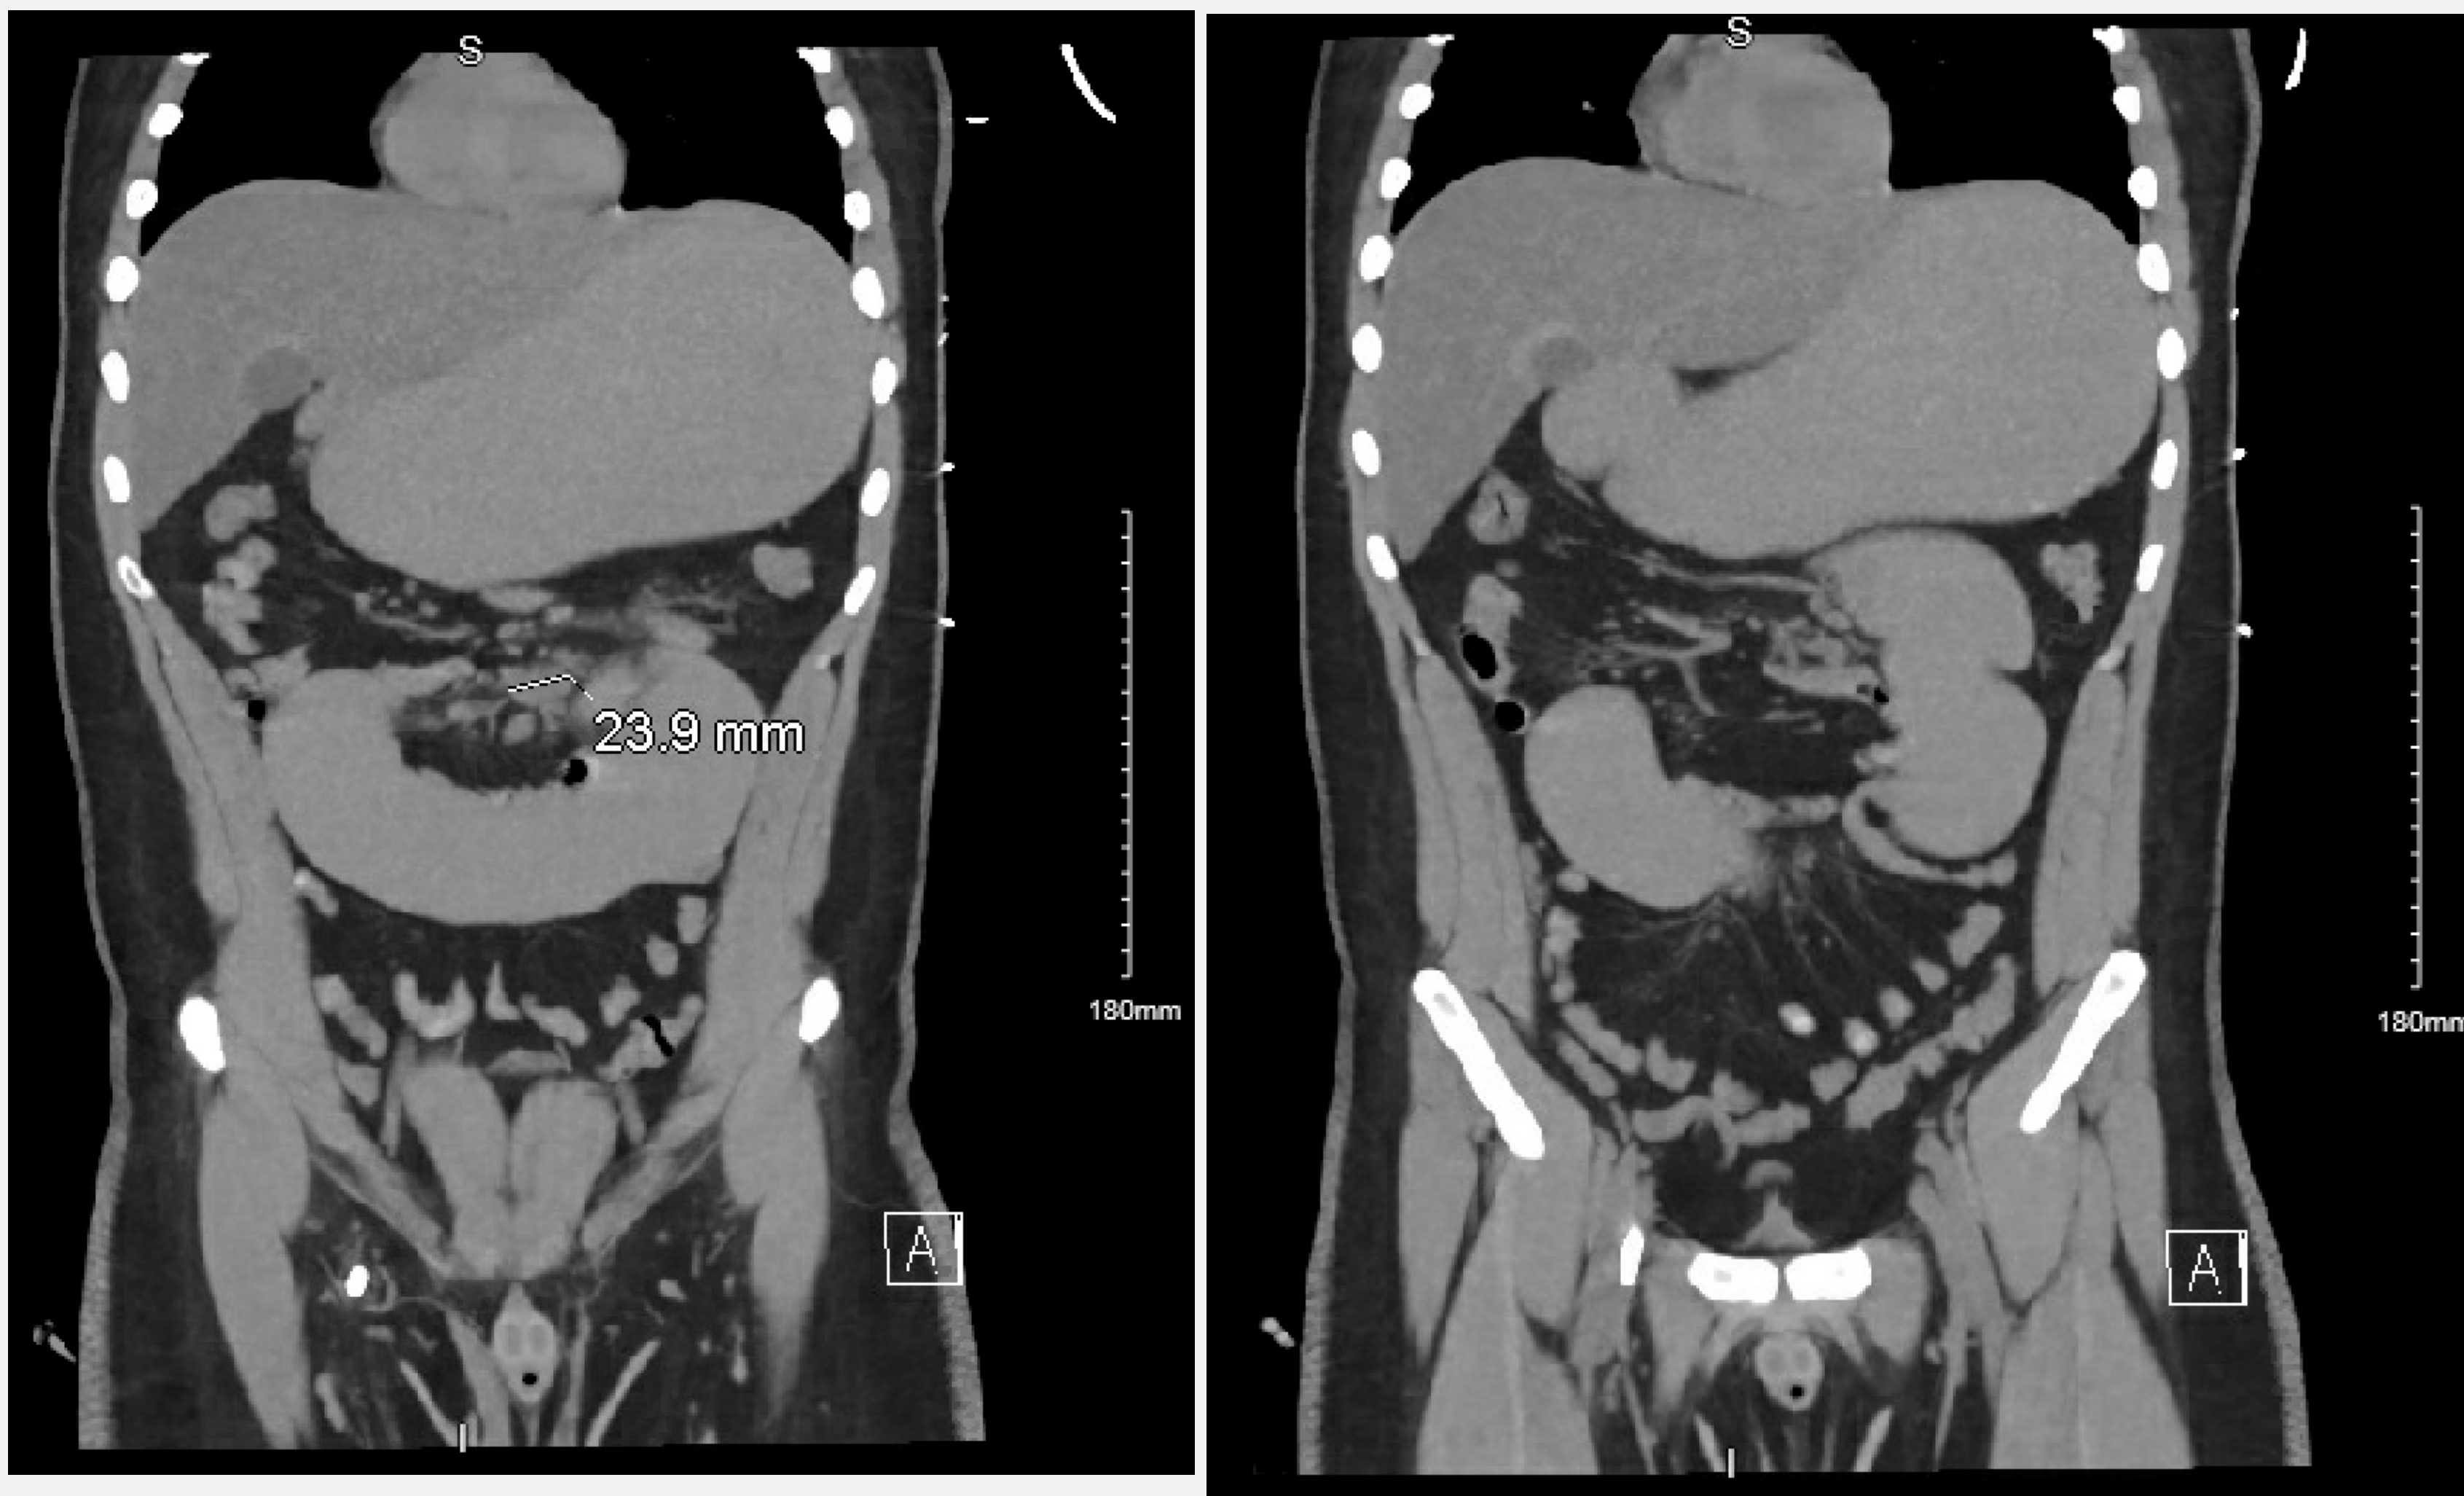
Dilation at the level of the duodenum noted on CT abdomen/pelvis as well as distal stricture at the level of the jejunum.
